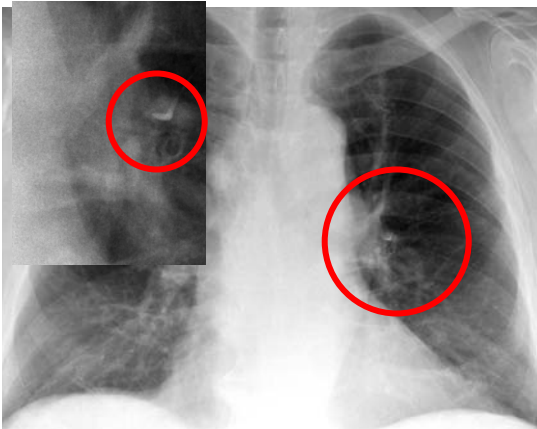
Chest x-ray film showing radio-opaque emboli in the left main pulmonary artery (enlarged view: left upper quadrant).
